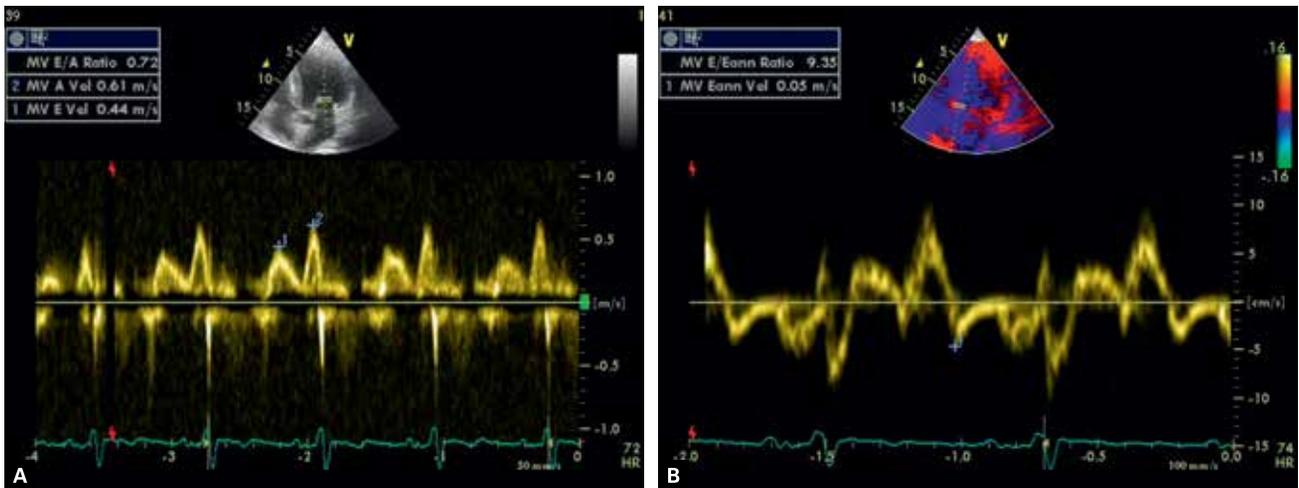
Transthoracic echocardiography. A. Pulse waved Doppler. B. Tissue Doppler. E/A = 0.72. E/E' = 9. Impaired relaxation of the left ventricle
